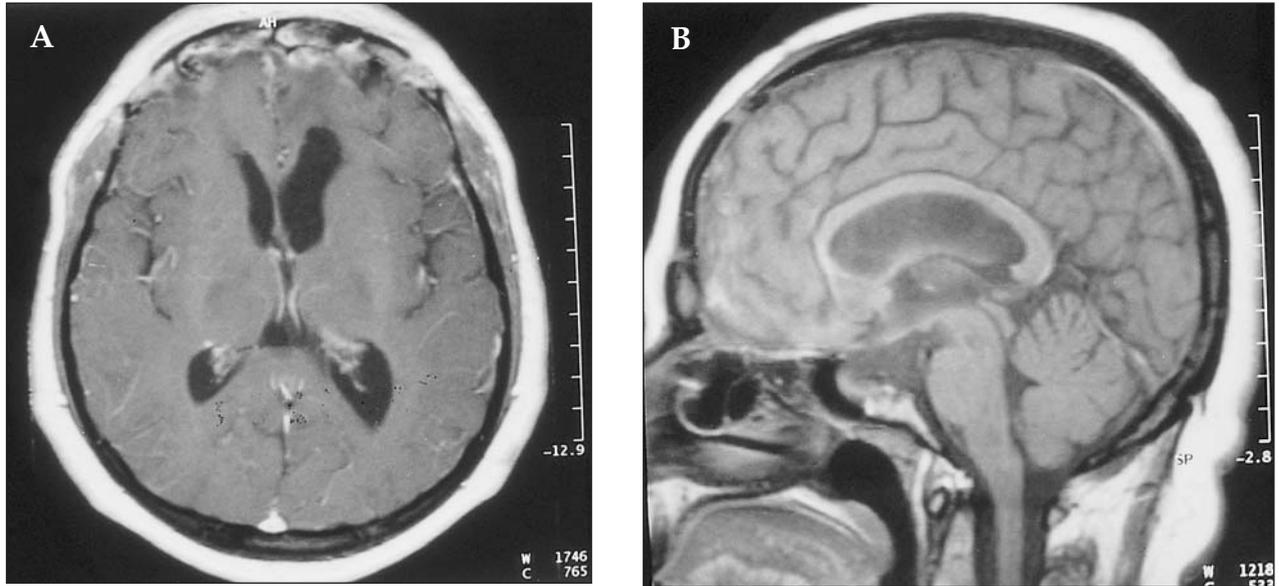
A, B: Post-operative axial and sagittal T1-weighted MRI
